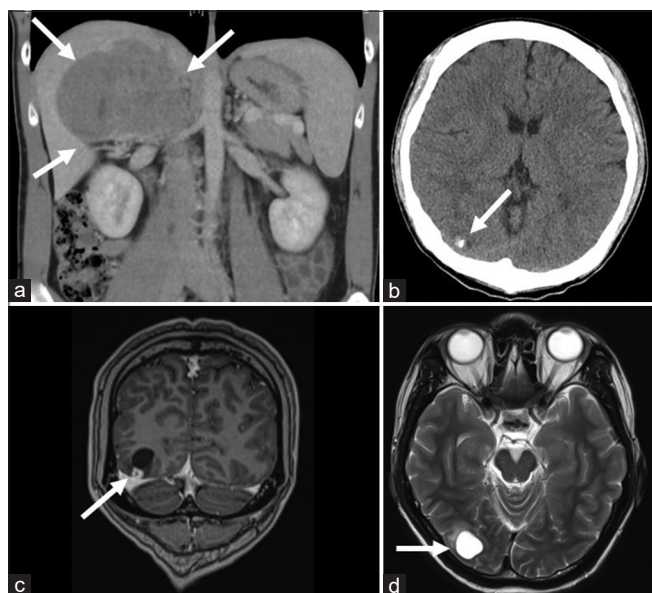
(a) Coronal image of computer tomography of the abdomen with contrast. Arrows marked the huge tumor in the hepatorenal fossa. (b) Axial plain computer tomography brain showed a hypodense lesion with calcification (arrow). (c) Coronal magnetic resonance imaging T1 sequence showed that the nodule had gadolinium contrast enhancement and was in contact with the tentorium (arrow). (d) Axial plain magnetic resonance imaging T2 sequence showed the cystic portion of the tumor (arrow)
